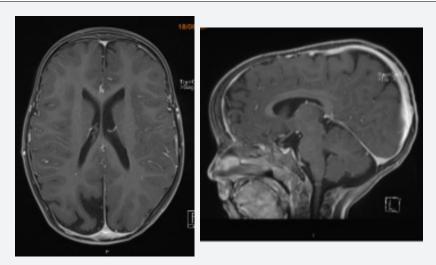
49 weeks post diagnosis: MRI axial and sagittal T1 weighted with gadolinium.
